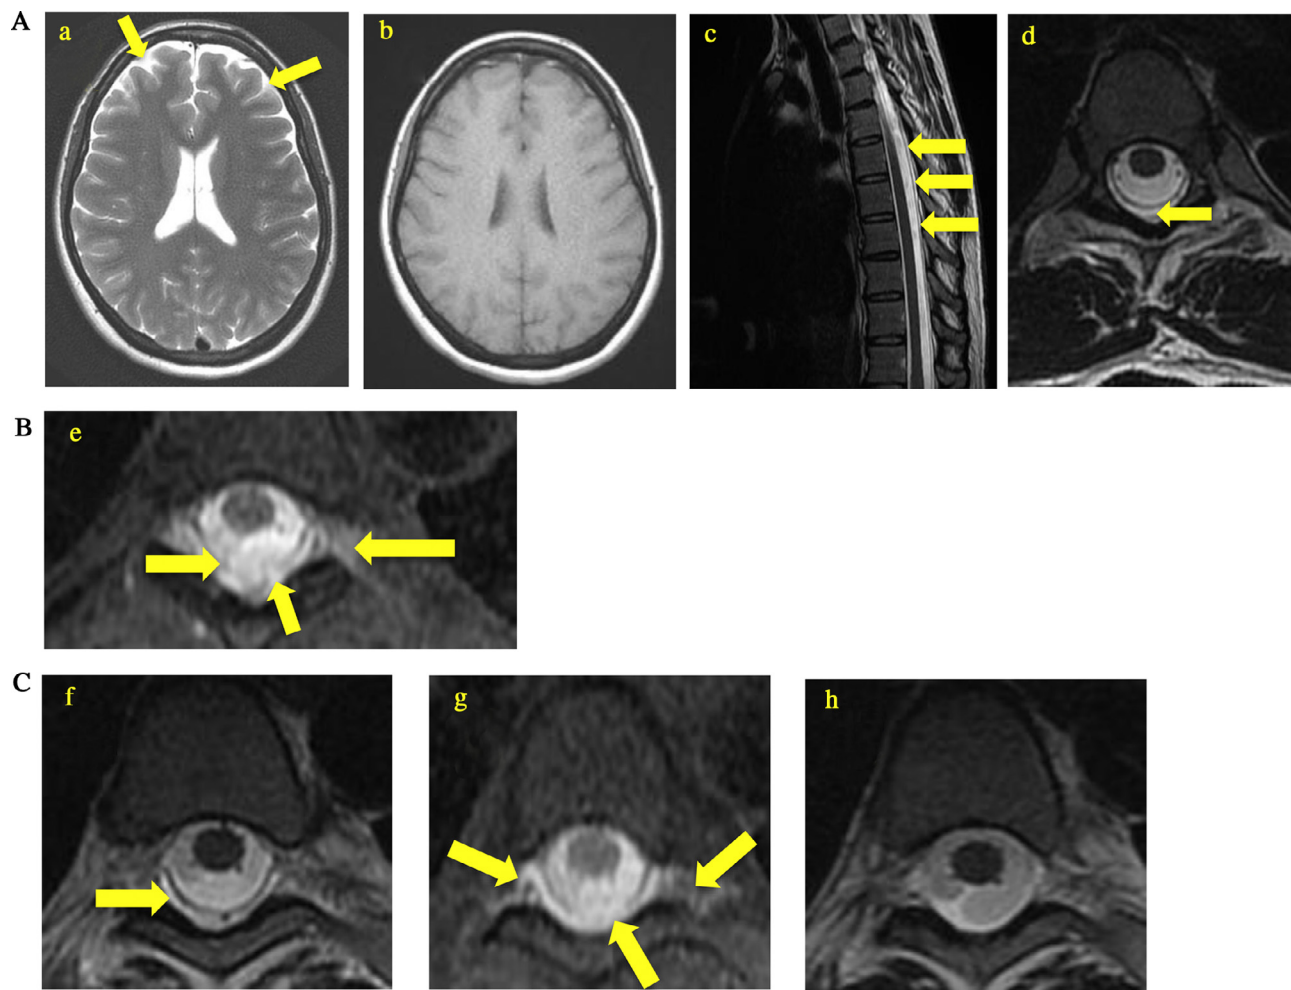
A. Indirect signs of intracranial hypotension on MRI.
